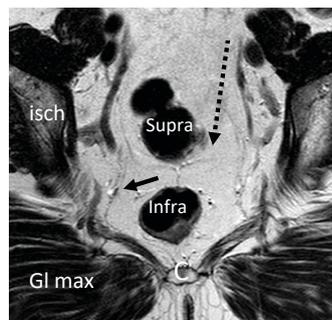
Coronal T2-w MR image taken at the level of the “H-shaped” morphology of the endopelvic fascia (short arrow) joining the peritoneal reflection (long dotted arrow) which separates the supra from the infra mesocolic rectum
